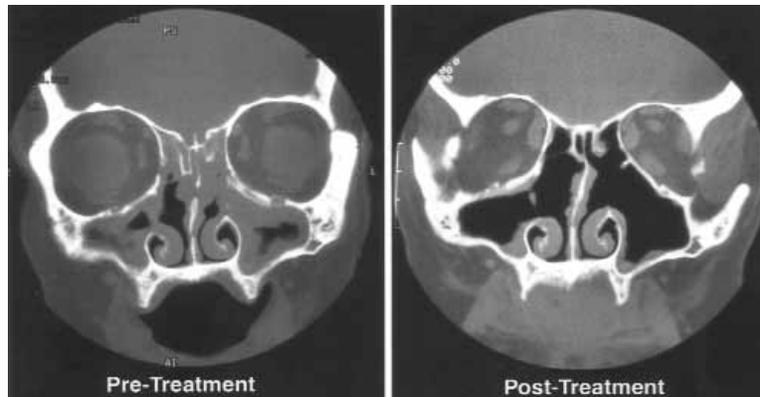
Coronal CT scan of patient with CRS demonstrates inflammatory mucosal thickening partially occluding the nasal cavity and paranasal sinuses before (left) and after (right) 4 months of intranasal treatment with amphotericin B.
